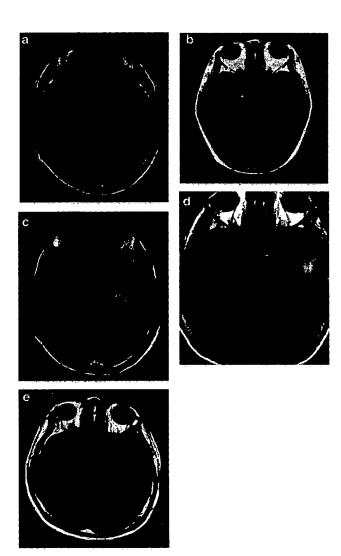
MRI of cases 1–5 (a–e, respectively), each depicting a lesion in the unilateral (cases 1 and 2, right; cases 3–5, left) amygdala.
